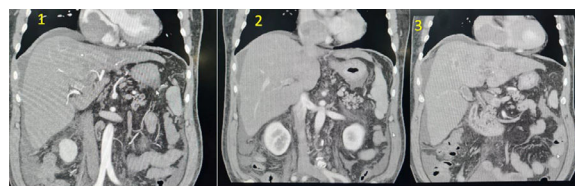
Triphasic computed tomography. 1) Arterial phase: arterial enhancement stronger than the surrounding liver (wash-in). 2) Venous phase: hypodensity or hyposignal intensity compared to the surrounding liver (wash-out) in the venous phase.
